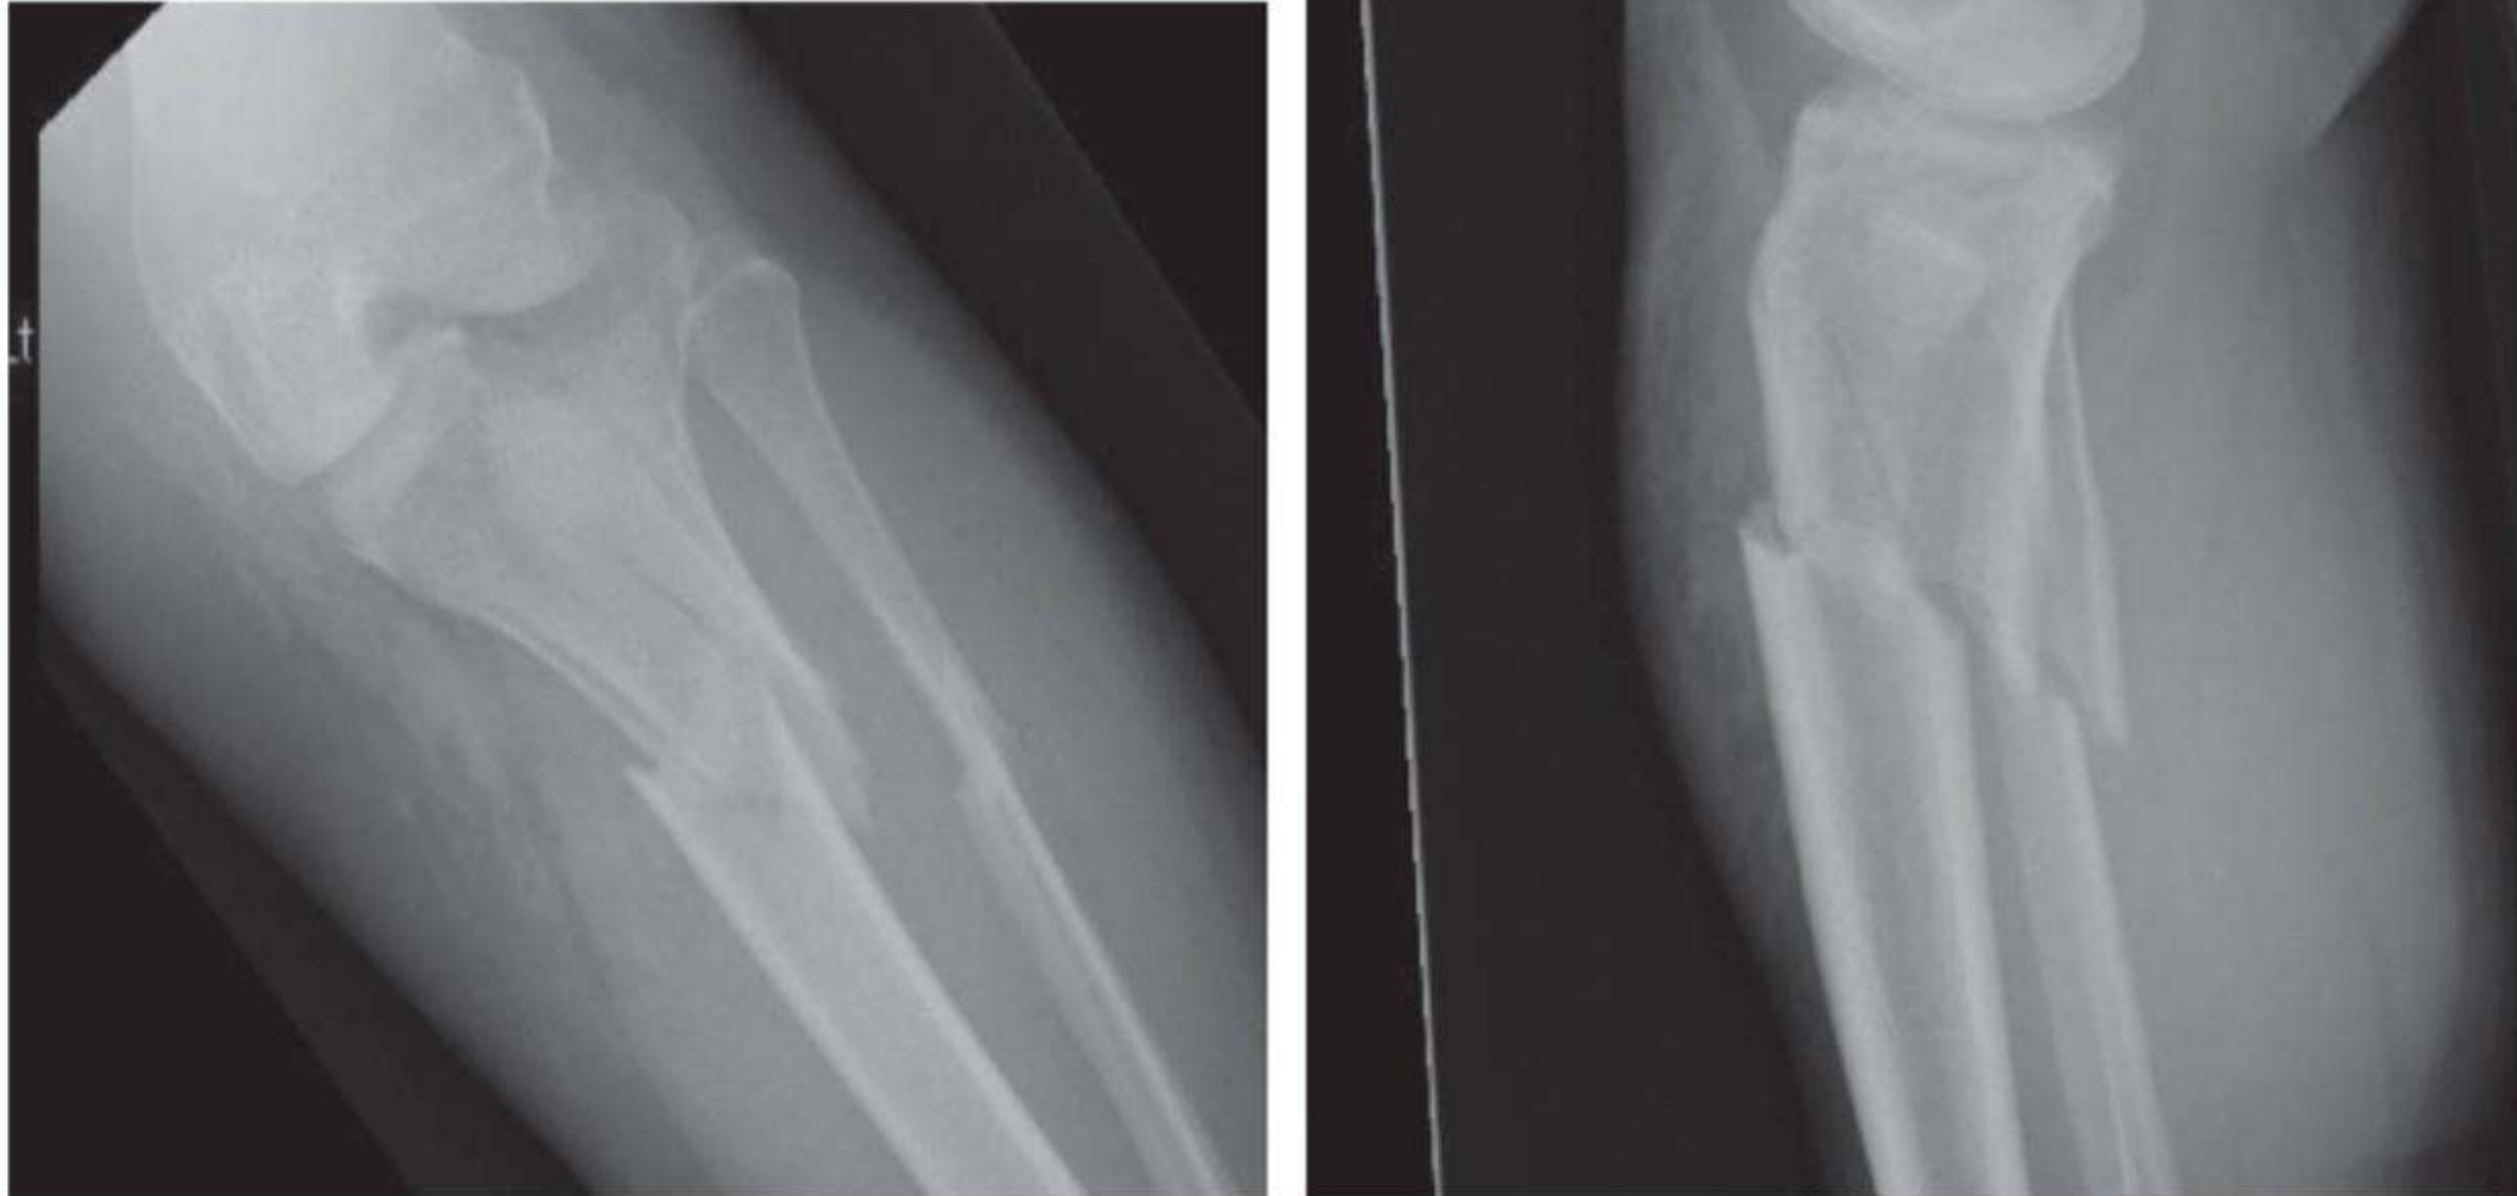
AP and lateral radiograph of proximal tibia
